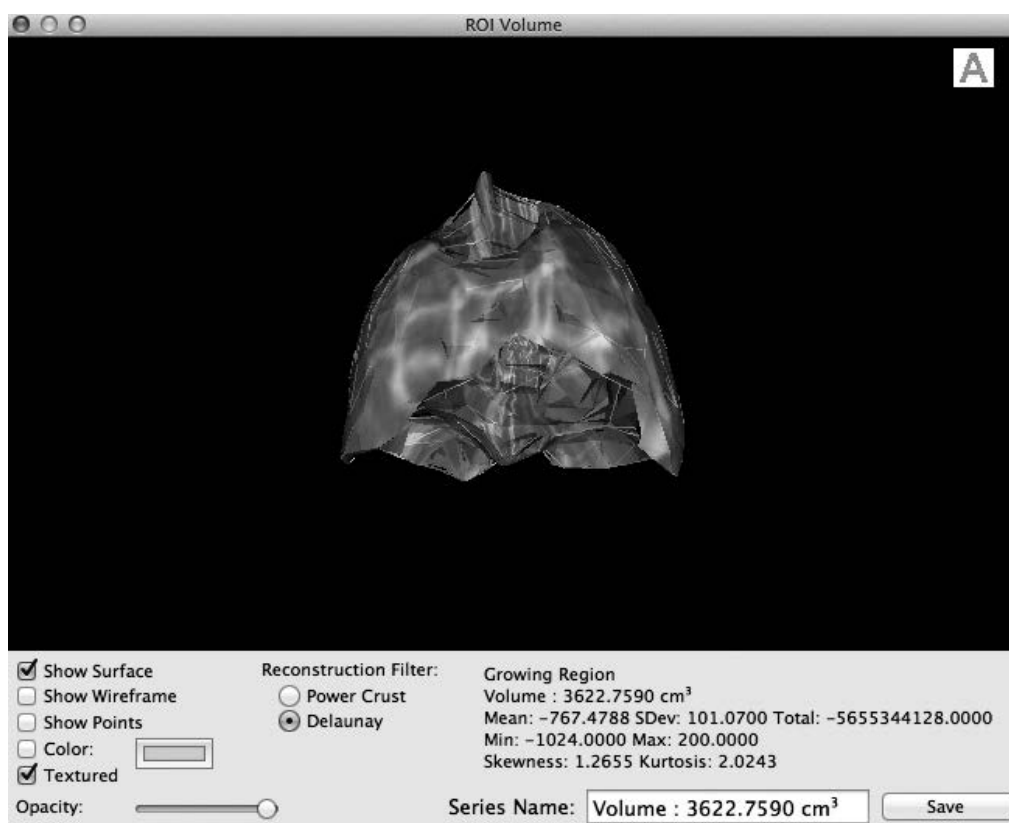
Example of OsiriX 3D ROI (Region Of Interest) lung CT indexes window. The final output of the segmentation process and CT indexes computation consists of a tridimensional lung reconstruction (above) with a list of the related attenuation parameters (third column below, under “Growing Region”).
